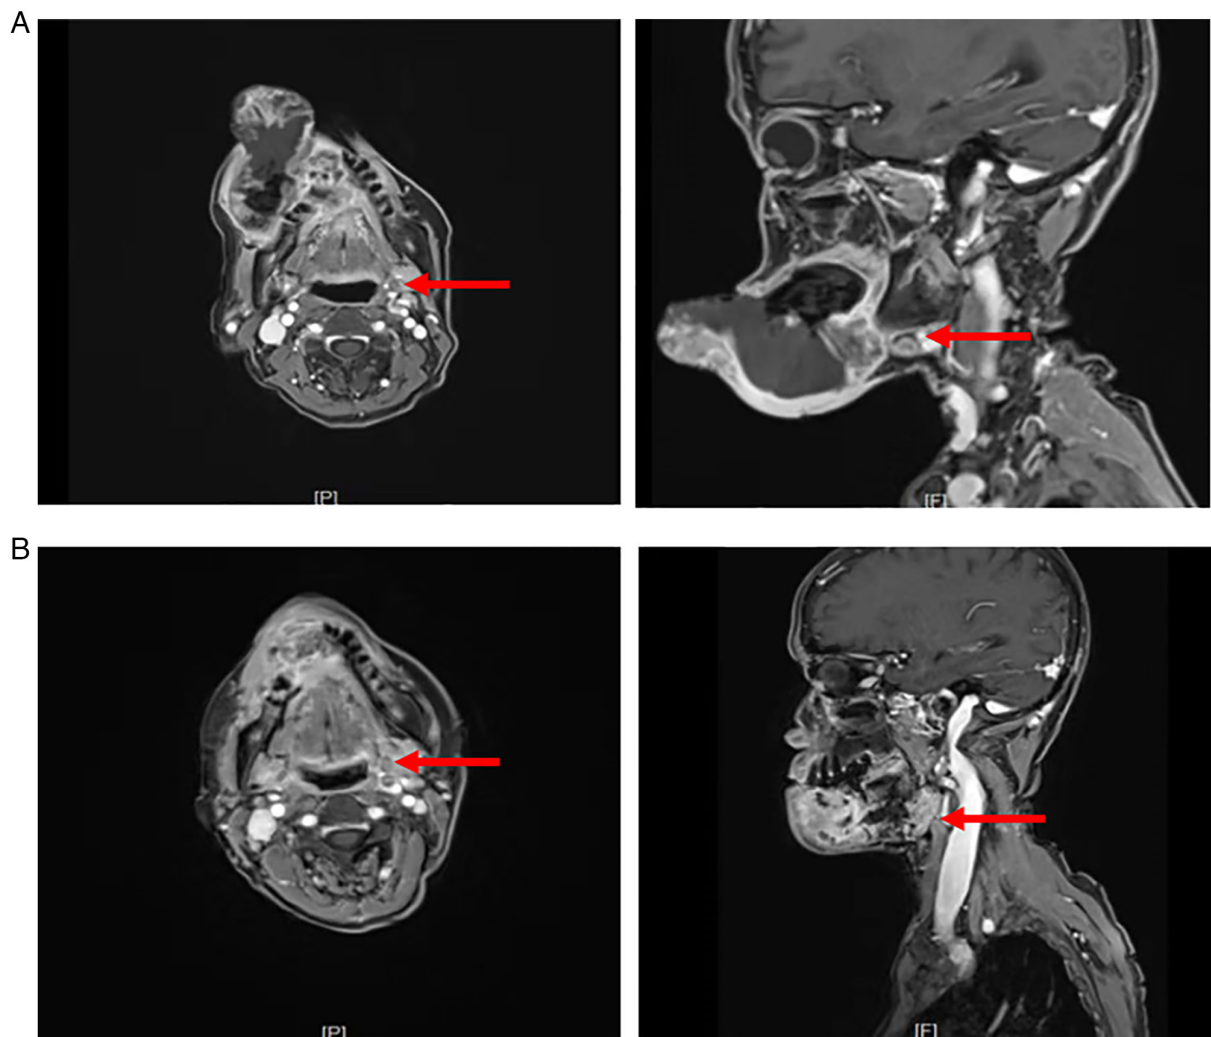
MRI images using T1 weighted imaging. (A) Before treatment, invasion of the bilateral sublingual glands, genioglossus muscle, right masseter muscle and lower lip soft tissue was observed. Red arrows indicate metastatic lymph nodes. (B) After treatment, the mandibular tumor was smaller and the metastatic lymph nodes in the neck were decreased in number and size.
